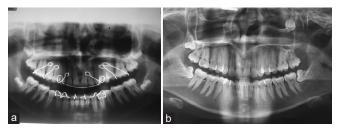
(a) Orthopantomogram taken during 12 years of age showing third molar tooth developing in normal position and (b) orthopantomogram taken presently shows the ectopic third molar in the inferior border of orbit and haziness in the left maxillary sinus
